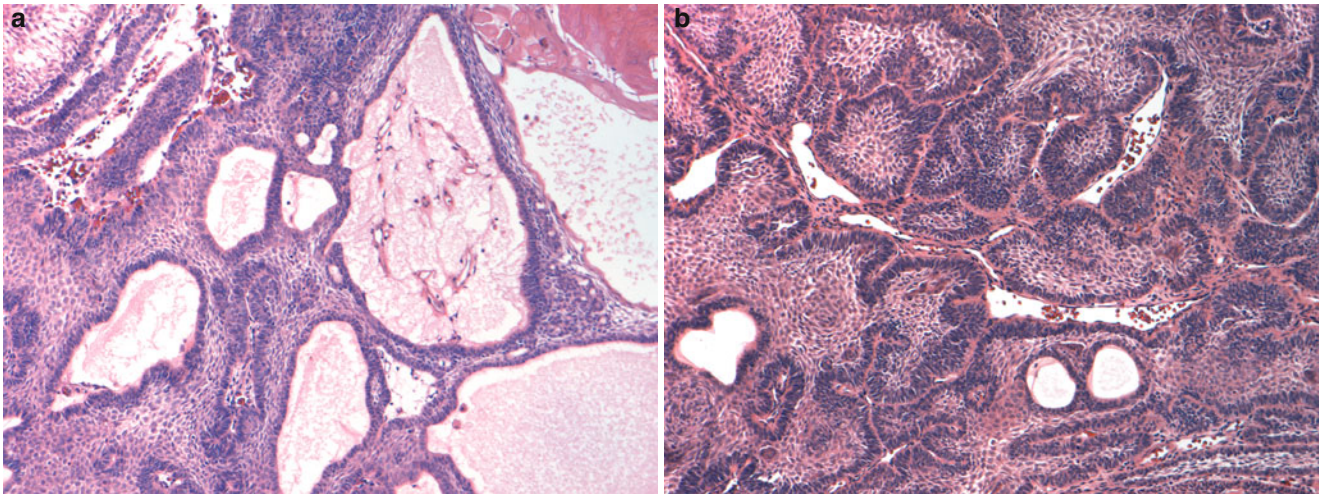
Craniopharyngioma. Three-month-old female with upward gaze nystagmus and a suprasellar mass (with enhancement) detected on CT scan. (a) The tumor consists of epithelial cells forming compact masses or lining cysts. (b) Nests of epithelial cells are surrounded by a
